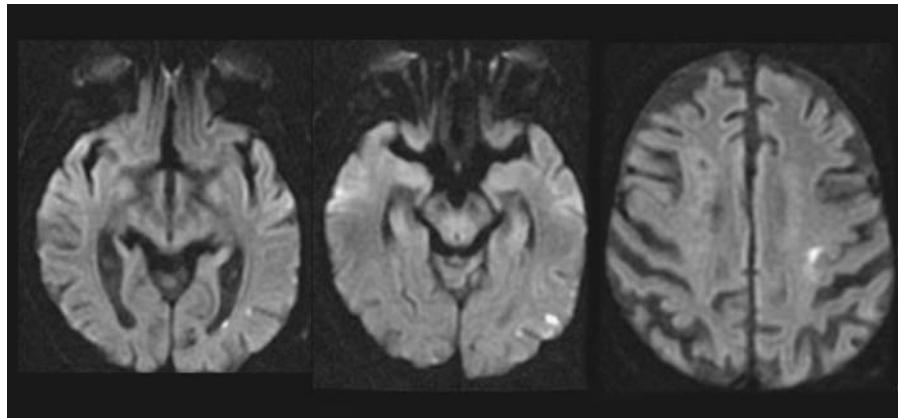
Transient ischemic attack. Sixty-one-year-old female with transient right hand, arm, and leg weakness. DWI images demonstrate punctate hyperintense lesions, consistent with acute infarctions, in the left occipital and frontal lobes. Abbreviation: DWI, diffusion-weighted images.
